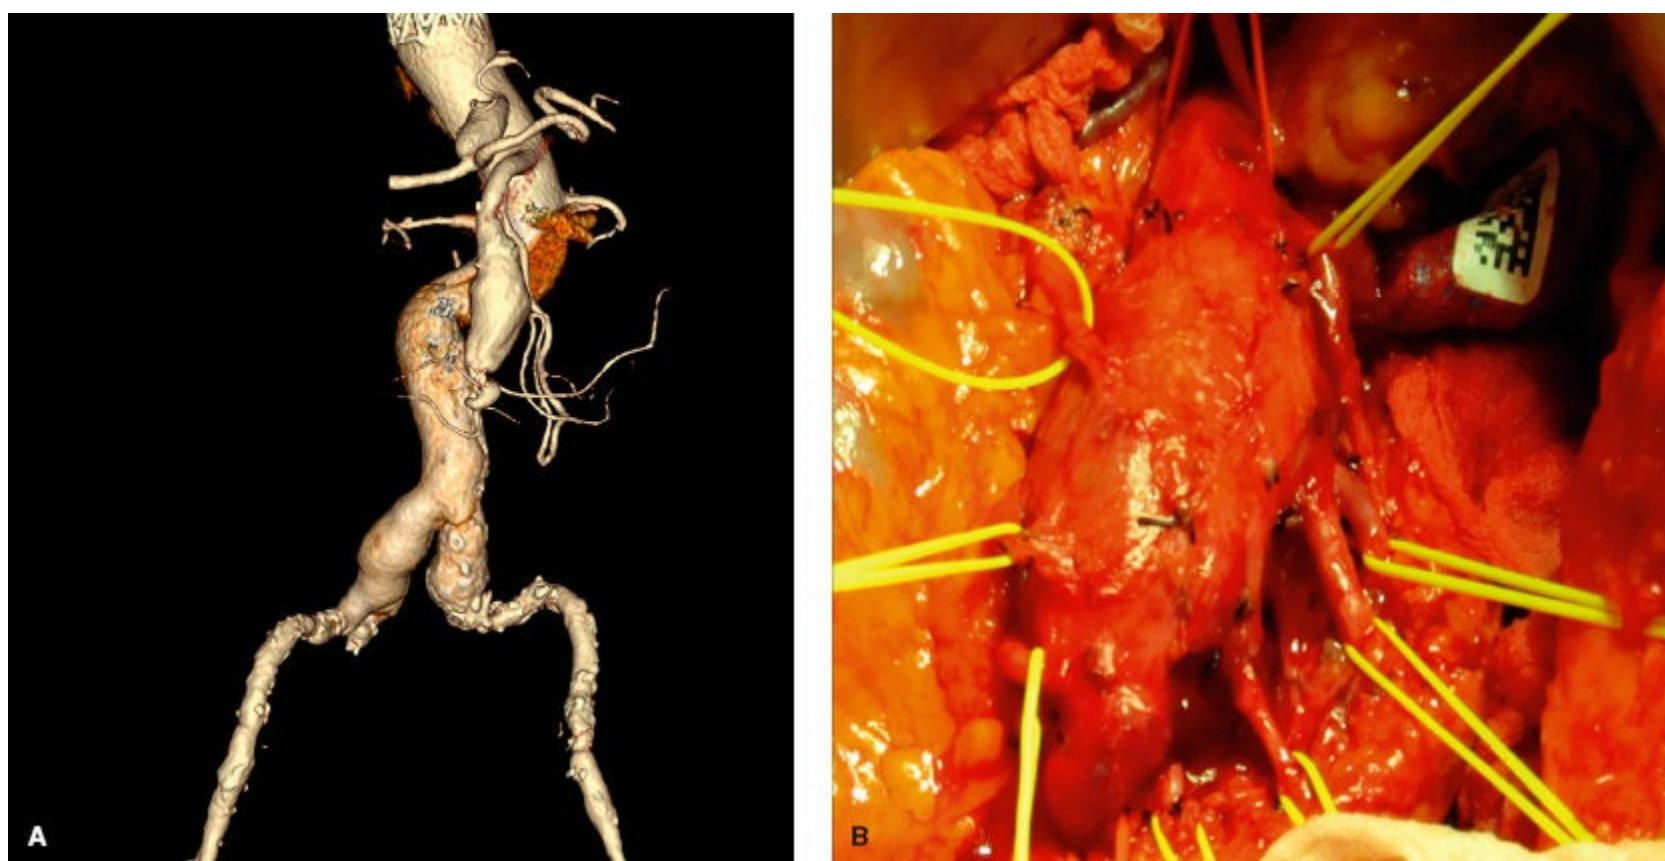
(A) CT angiogram and (B) intraoperative photo of a large 3.6-cm asymptomatic SMA aneurysm associated with extensive thoracoabdominal aortic and SMA dissection. The aneurysm was repaired by way of an SMA interposition bypass graft using nonreversed great saphenous vein; additionally the proximal SMA dissection flap was sharply fenestrated.
